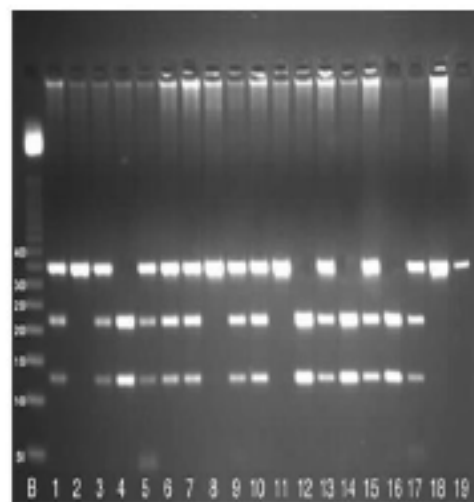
B: Marker (50 bp DNA Leader); 1,3,5,6,7,9,10,13,15,17=CT;2,8,11,18=cc; 4.,12, 14,16=TT; 19-uncut
